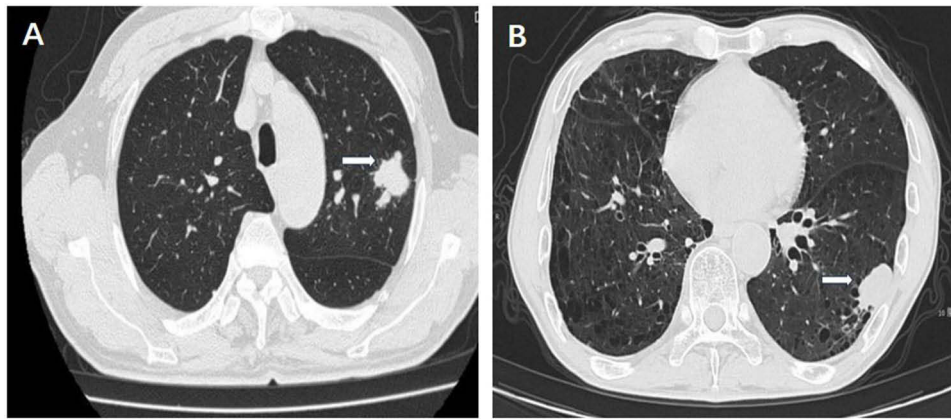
Computed tomography scan of SMARCA2-deficient lung adenocarcinoma. An irregular nodule exhibiting a lobulated morphology and spiculated margin was identified in the left upper lobe of the lung (A, white arrow). Nodular high-density opacities are observed in the lower lobe of the left lung, exhibiting lobulated features with poorly defined margins (B, white arrow).
